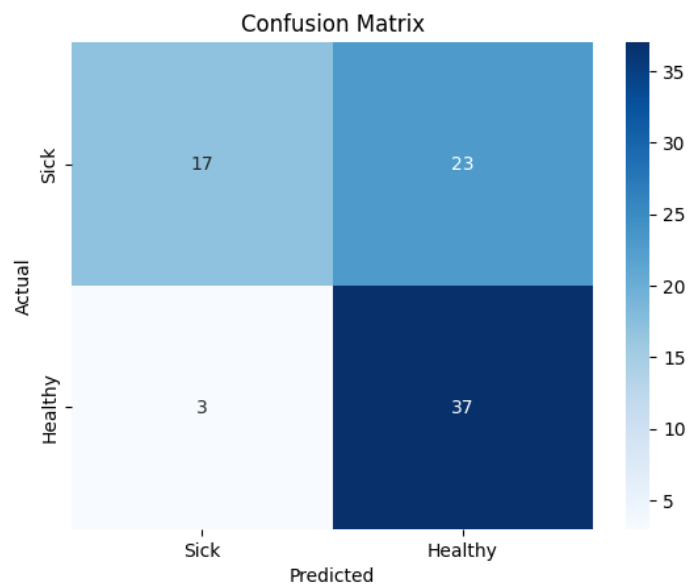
Confusion matrix of the ResNet+KAN model on the test set, showing classification outcomes for healthy and sick MRI scans.
